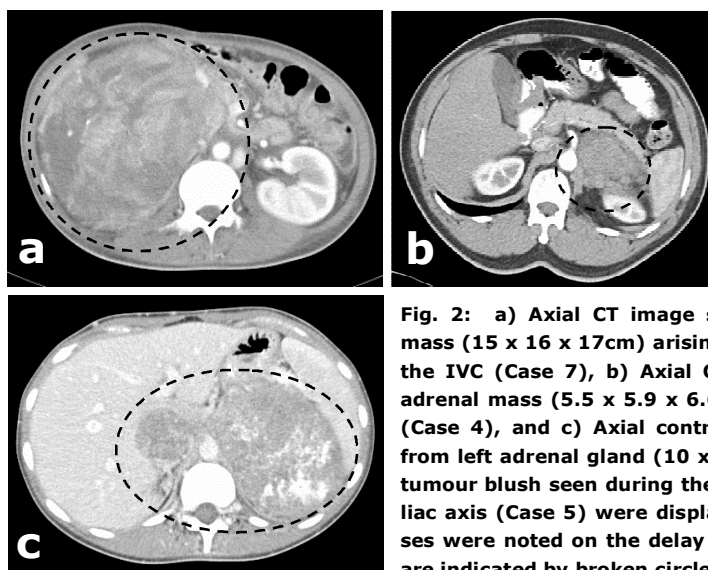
a) Axial CT image showing a large enhancing heterogeneous mass (15 x 16 x 17cm) arising from the right adrenal gland compressing the IVC (Case 7), b) Axial CT showing a left heterogeneous enhancing adrenal mass (5.5 x 5.9 x 6.6cm) encasing the left renal artery (arrow) (Case 4), and c) Axial contrast CT showing a hypodense mass arising from left adrenal gland (10 x 12 x 15cm) with an IVC tumour thrombus-tumour blush seen during the arterial phase. The splenic artery and coeliac axis (Case 5) were displaced by the tumour. Multiple liver metastases were noted on the delay phase without contrast wash out. Tumours are indicated by broken circles
